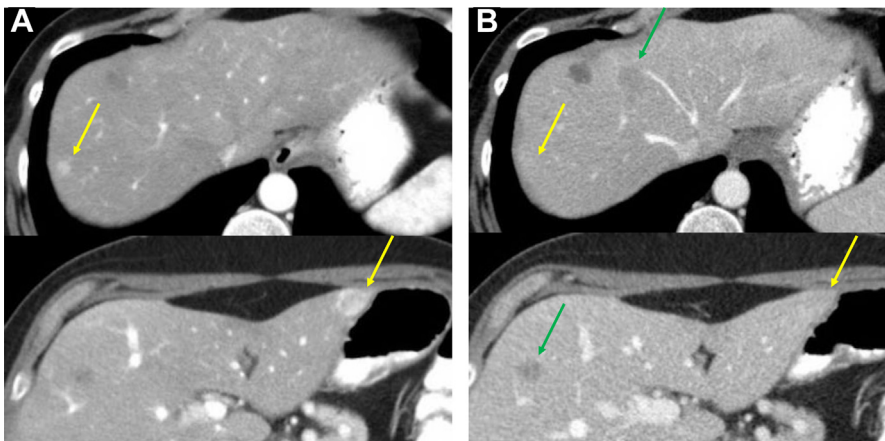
Hepatic metastases from G2 PNET. Multiphase contrast enhanced CT, arterial (A) and portal venous (B) phases. Some lesions are arterially enhancing and seen only on the arterial phase (yellow arrows), others are hypoenhancing and better visualized on the venous phase (green arrows).
